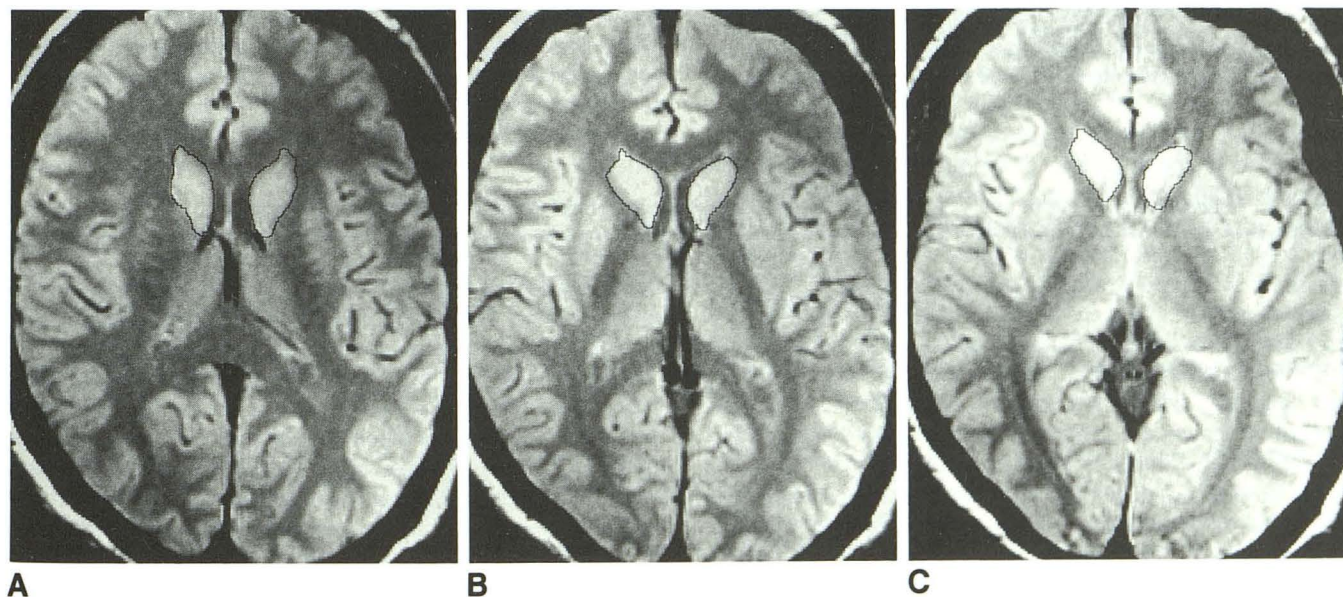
Measurement of caudate volume on MR images (2500/30/1).
